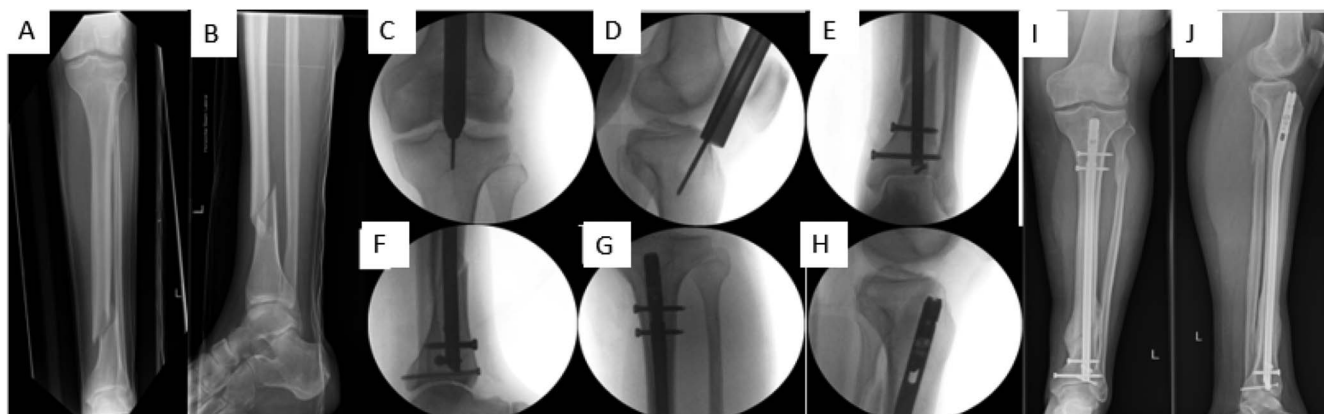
A 32-year-old man sustained a closed distal tibial shaft fracture while playing football. A and B, Preoperative tibia radiographs showing the fracture pattern. C, D, E, F, G, and H, Intraoperative fluoroscopic images showing the stabilization of the fracture with the Bactiguard-coated natural nail. I, J, Postoperative radiographs showing fracture union 4 months postoperatively.
